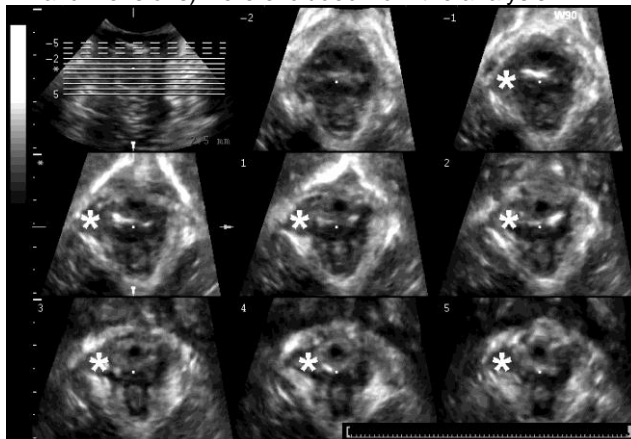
Tomographic ultrasound imaging (TUI) of a levator avulsion (marked by*).
